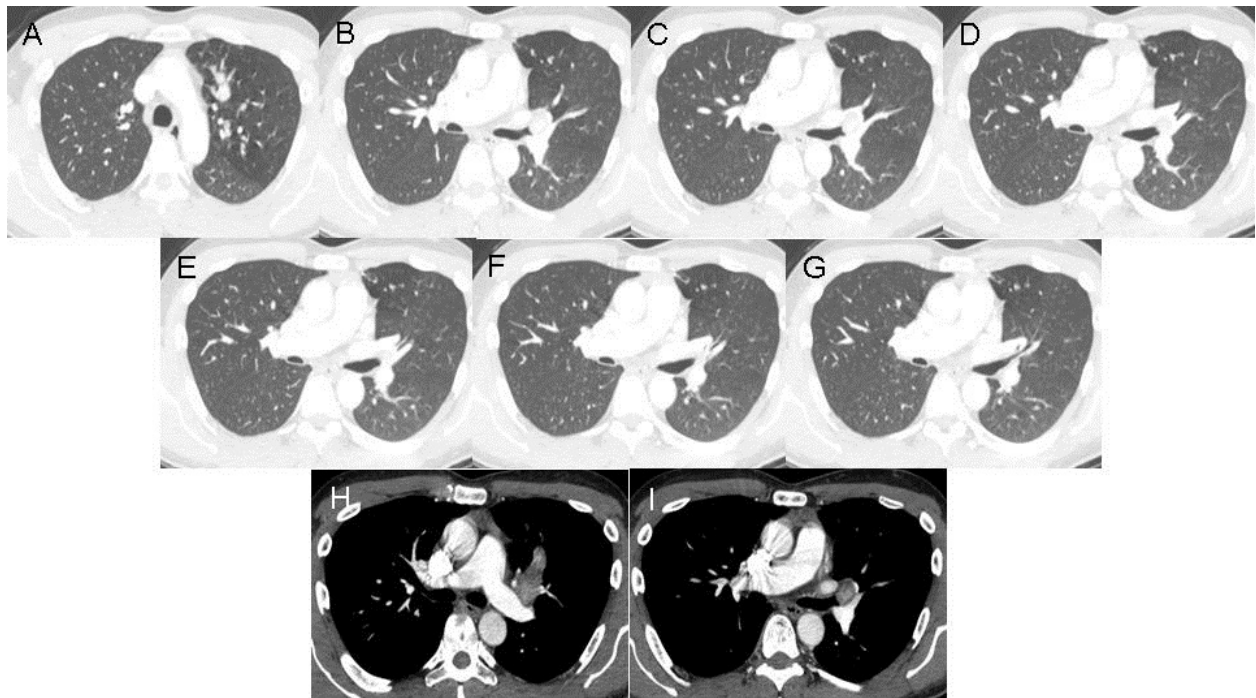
Axial thoracic CT scan (A-G= lung windows, H-I soft tissue windows).
